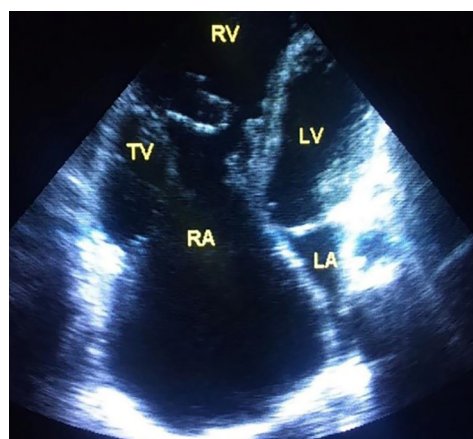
Two-dimensional echocardiography apical 4 chamber view Ebstein anomaly of the tricuspid valve
